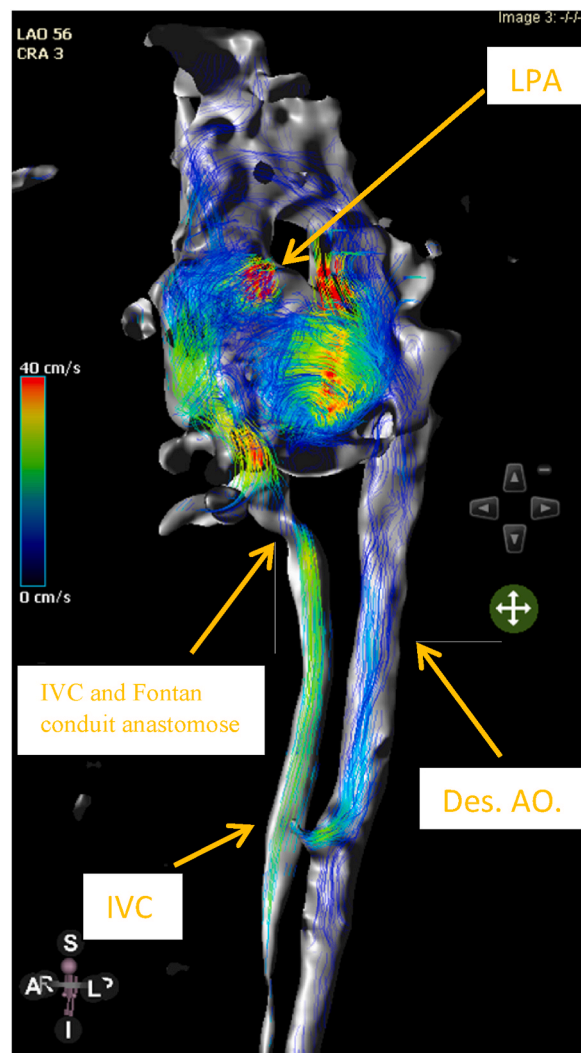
4D flow MRI map shows a high velocity at the Fontan conduit close to the origin of left pulmonary artery indicated by arrows. Anatomical parts of the Fontan circulation.
